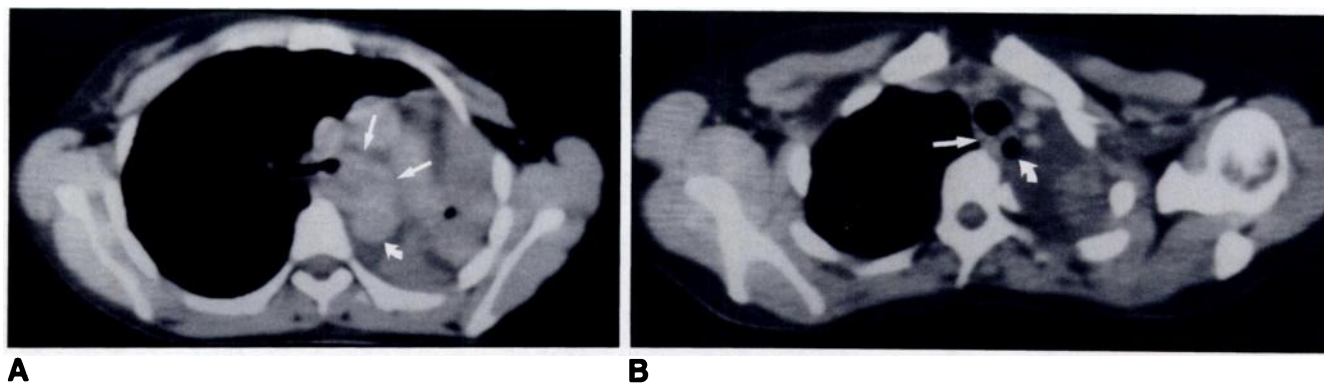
A, CT image at level of right upper lobe bronchus demonstrates total occlusion of left mainstem bronchus by adenoid cystic carcinoma. There is mediastinal extension (arrows) and collapse of left lung with leftward mediastinal shift. No fat plane between descending aorta (curved arrow) and tumor
